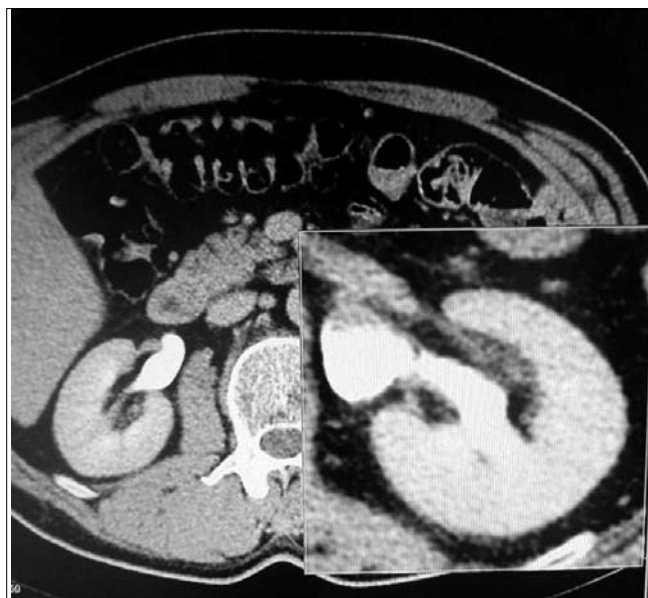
Same patient-CT: left renal pelvis tumor.
